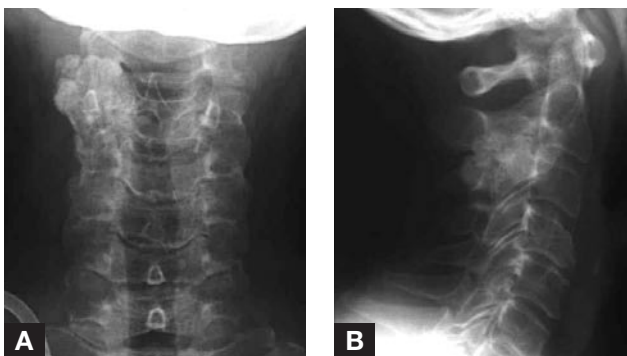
Plain anteroposterior (A) and lateral (B) radiographs of cervical spine show lobulated calcified mass at right C2-C3 facet joint.
